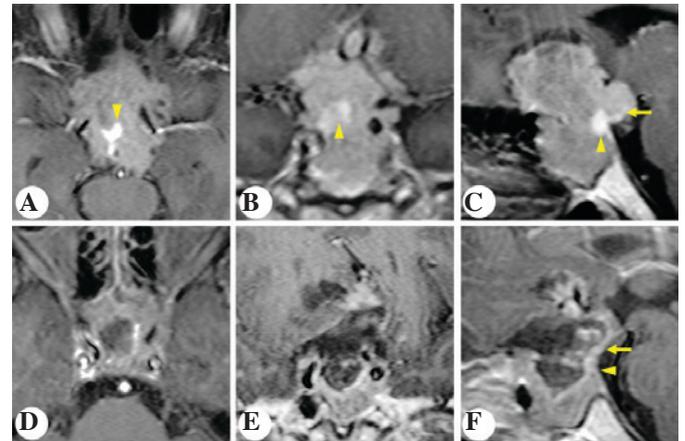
Patient 4*. Representative post contrast T1-weighted images. Preoperative (A) horizontal, (B) coronal and (C) sagittal and postoperative (D) horizontal, (E) coronal and (F) sagittal magnetic resonance imaging of the sellar region. Arrows indicate the pituitary stalk. Arrowheads indicate the pituitary gland.
